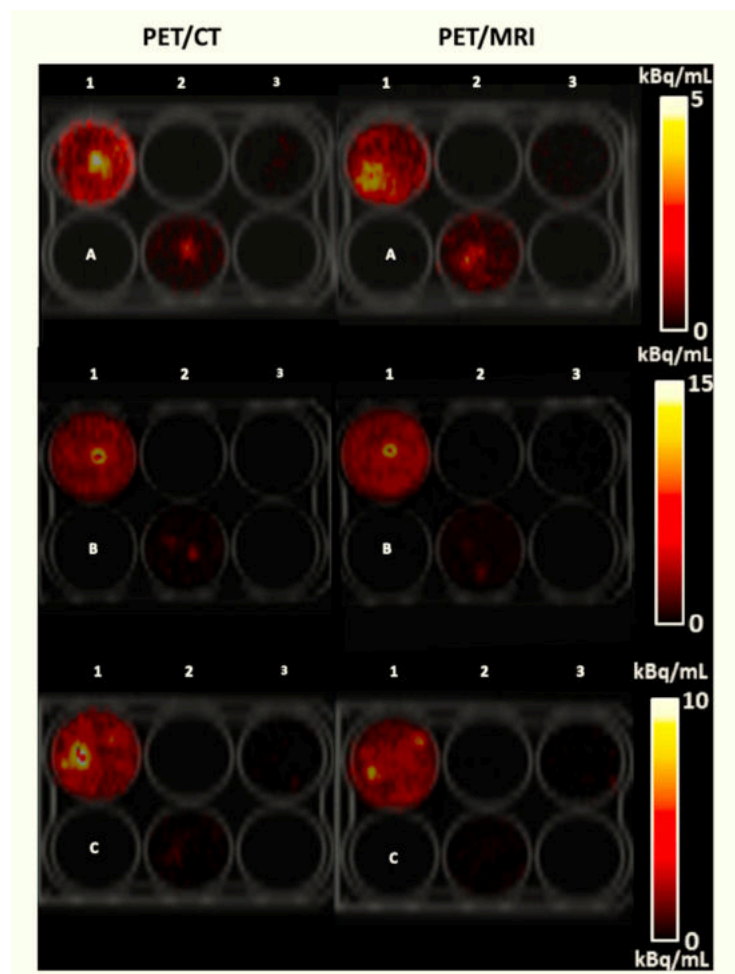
PET images of 6-well plates containing ^{89}Zr -labelled Jurkat cells acquired using PET/CT and PET/MRI together with their corresponding co-registered CT image. Cell numbers and specific activities per well ($\text{kBq}/10^6 \text{ cells}$; indicated parenthetically) were as follows:
